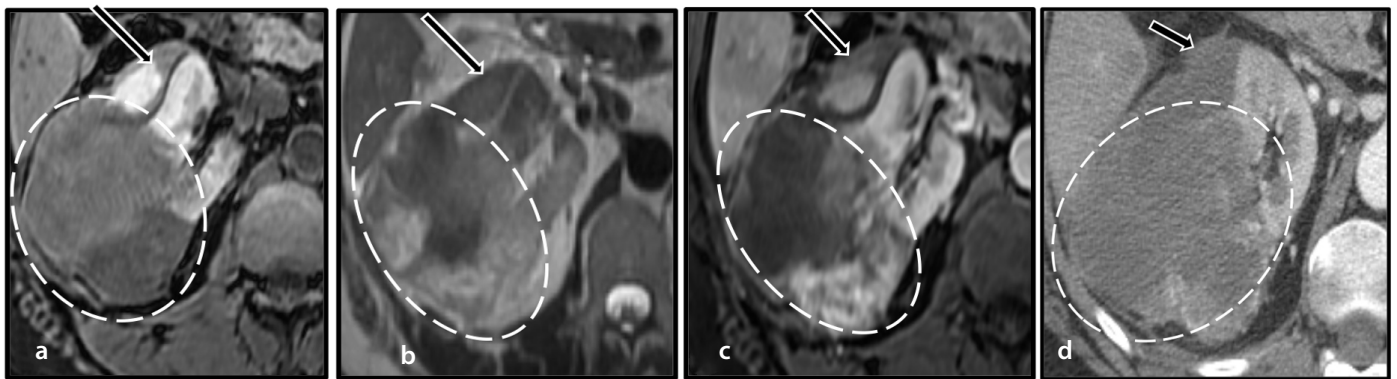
An axial MRI at the level of the right kidney (a-c) demonstrates a heterogeneous mass (white circle) with regions showing a non-enhancing, mildly T1 hyperintense signal, suggesting hemorrhage/necrosis. The findings are consistent with the patient's known renal cell carcinoma. An associated subacute subcapsular hematoma (black arrows) compresses the renal parenchyma. (d) An axial contrast-enhanced CT of the right kidney demonstrates the mass (white circle) and associated subcapsular hematoma (black arrow). MRI, magnetic resonance imaging; CT, computed tomography.
